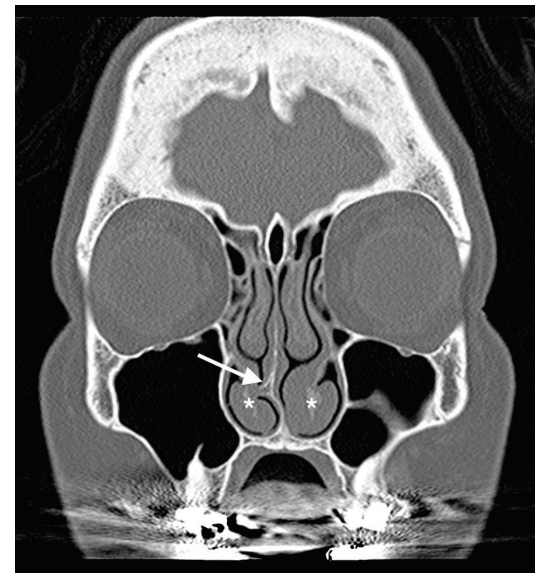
Coronal CT scan of the nasal cavity demonstrating a deviated nasal septum to the right (arrow) and hypertrophied inferior turbinates (asterisks).
